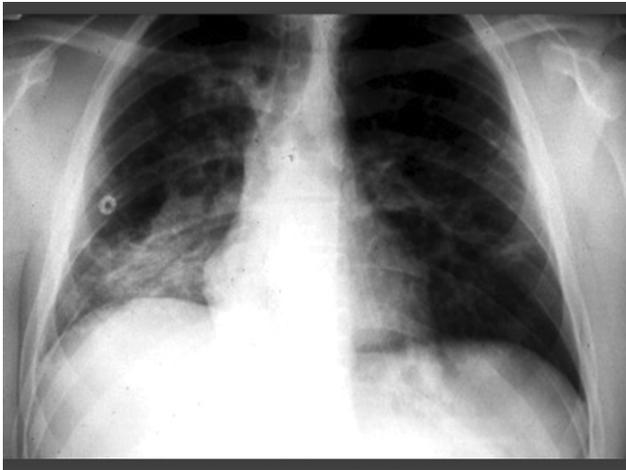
Initial chest radiograph showing a large infiltrate.
